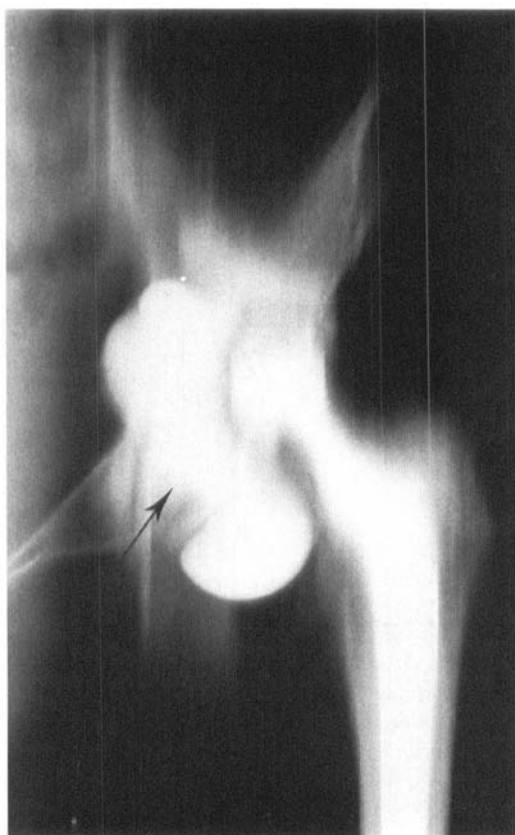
Tomogram anterior to the prosthesis following puncture and injection of water-soluble contrast into the bursa. No communication with the hip joint was found. The intermediate part of the bursa, obscured by the prosthesis on plain films, is clearly demonstrated on this tomographic section (arrow).
